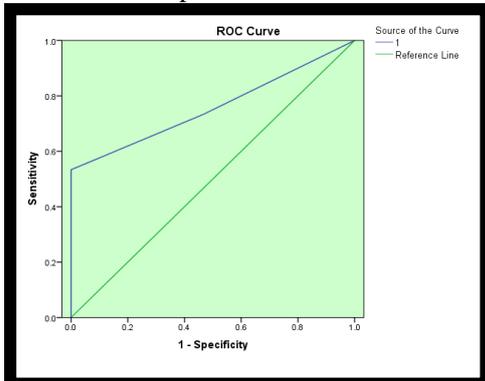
Receiver operating characteristic ROC plot: Bitewing radiograph at enamel threshold for proximal surfaces
